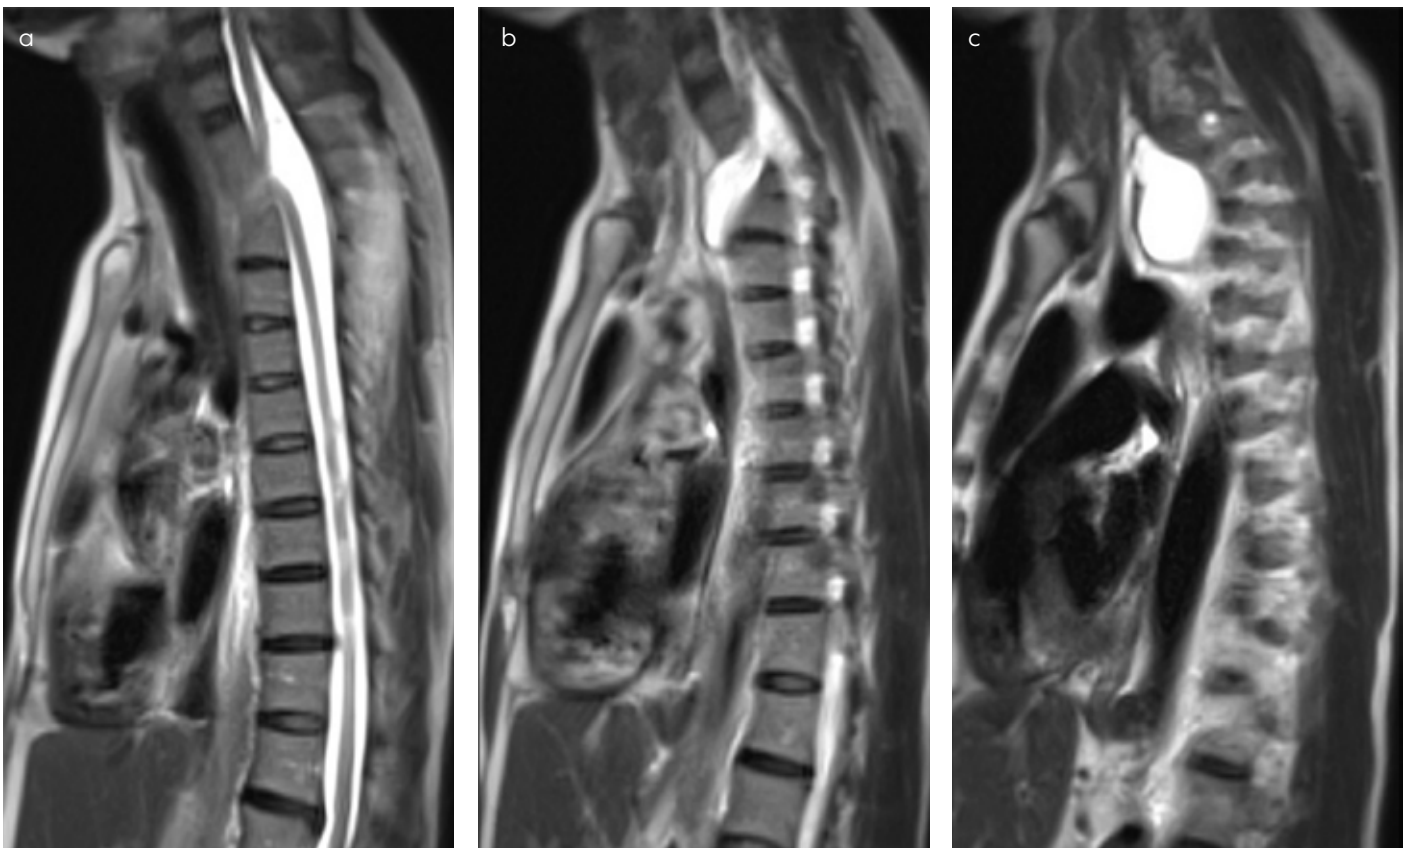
a-c. Sagittal (a-c) MRI scan showed a homogenous cystic mass in left hemithorax, communicating with the spinal canal through the anterior aspect of the 11th thoracic vertebrae
